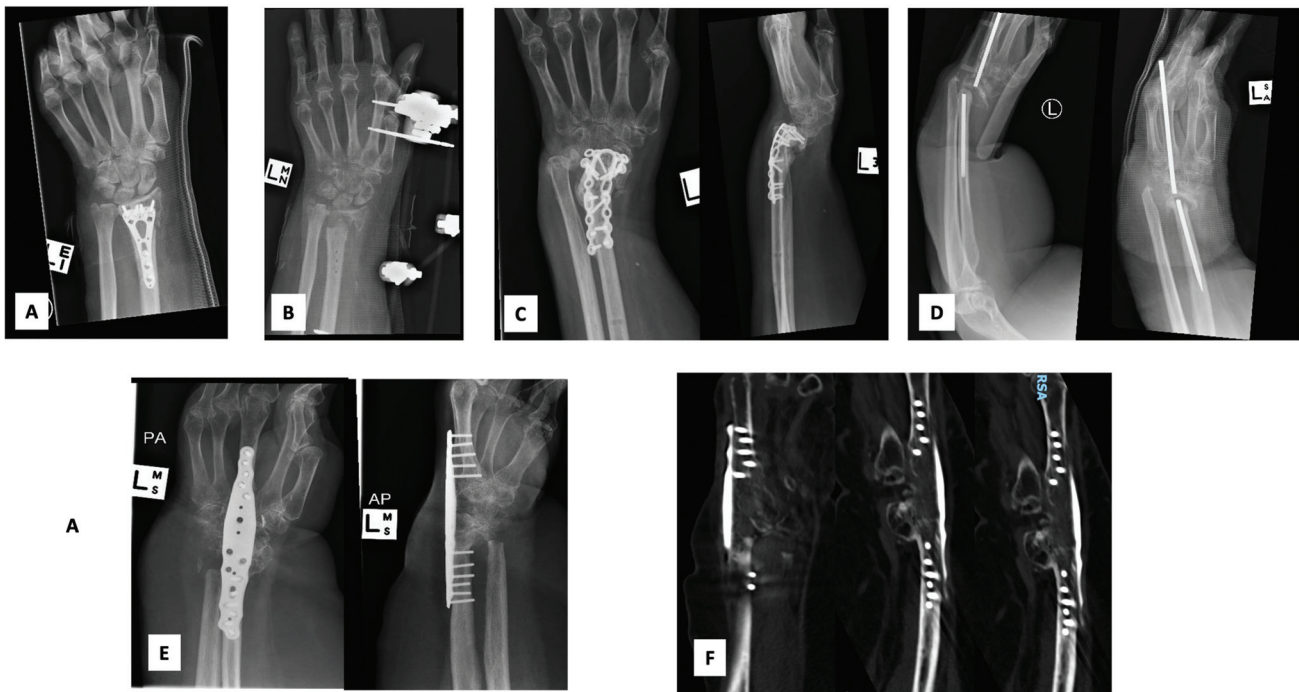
Case 1: a 54-year-old woman. (A) Initial distal radius fracture reduction and internal fixation with a volar locking plate. (B) The wrist became infected and the hardware was removed and an external fixator was applied. (C) Revision fusion with iliac crest bone graft failed. (D) Another attempt at wrist fusion with Steinmann pin also failed. (E) Definitive reconstruction with an MFC-CP flap and a spanning wrist fusion plate was performed. (F) Complete bony union of the wrist was confirmed on CT scan at 6 months.
